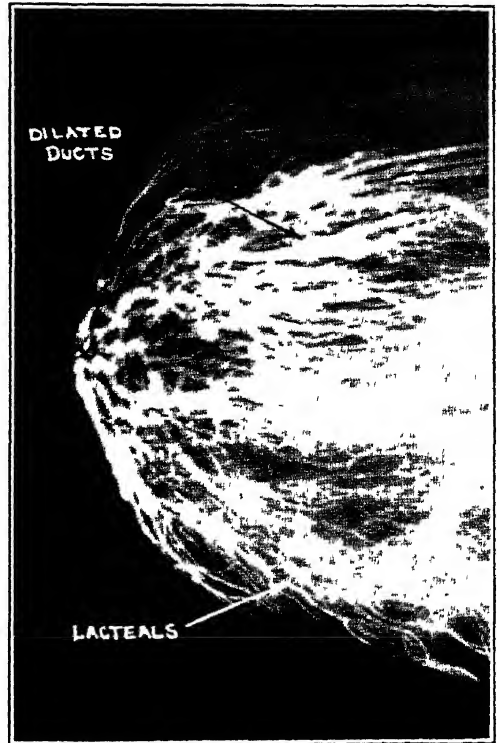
Ducts of multiparous breast were injected with lipiodine. The large dilated ducts and the dense network of large lacteals indicate a "good milk producer" (Am J Roentgenol, March, 1938)
